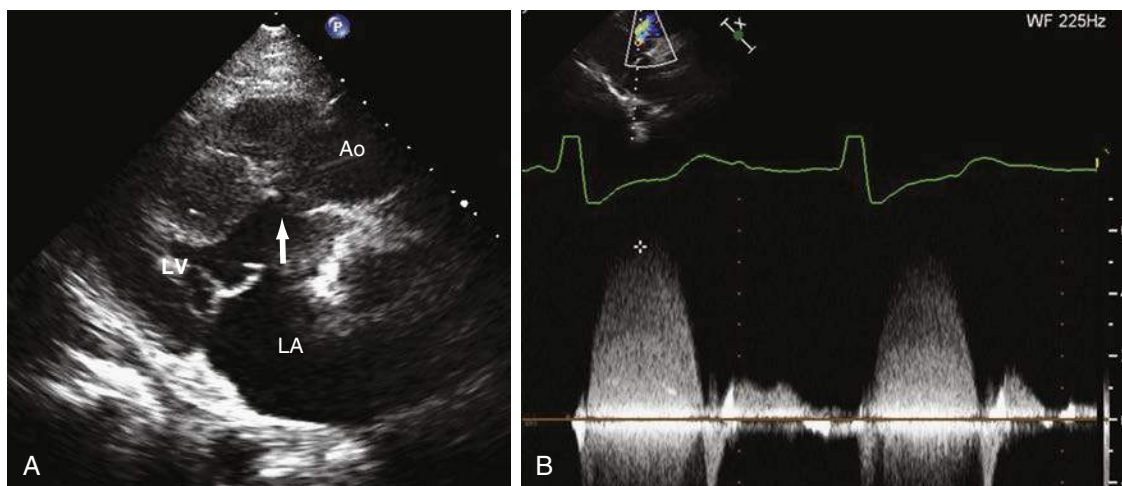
Transthoracic echocardiography from a patient with tricuspid atresia, ventricular arterial discordant transposition of the great arteries, after Fontan-type repair. There is a restrictive ventricular septal defect with the hemodynamic effect of severe subaortic stenosis. A, Two-dimensional image from the parasternal long-axis view. Note the dimensions of the ventricular septal defect (white arrow; the arrow is much smaller than the aortic root). B, Continuous-wave Doppler showing high flow velocity across the VSD. Ao, Aorta; LA, left atrium; LV, left ventricle.
